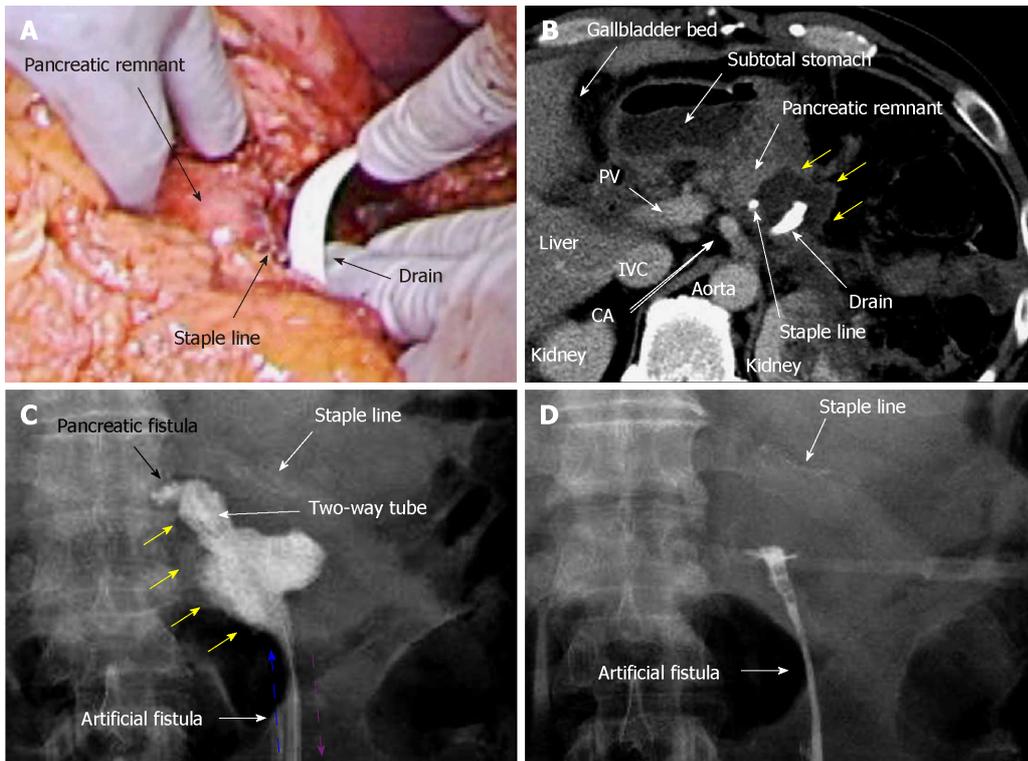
Case 2. A: Pancreatectomy was performed using a linear stapler, and we placed a drain near the staple line; B: Contrast computed tomography on postoperative day (POD) 9 revealed that intractable pancreatic fistula had led to an intraperitoneal abscess near the staple line (yellow arrows); C: Fistulography via the drain on POD 9 revealed intractable pancreatic fistula (black arrow) and the abscess cavity (yellow arrows). From POD 9, saline irrigation (blue arrow) was continuously injected into the abscess cavity via a two-way tube with the drainage route (purple arrow). Thereafter, amylase levels in the drainage discharge decreased immediately; D: Fistulography on POD 12 revealed that the abscess resolved after 4 d of continuous local lavage. CHA: Common hepatic artery; CLL: Continuous local lavage; IVC: Inferior vena cava; POD: Postoperative day.
